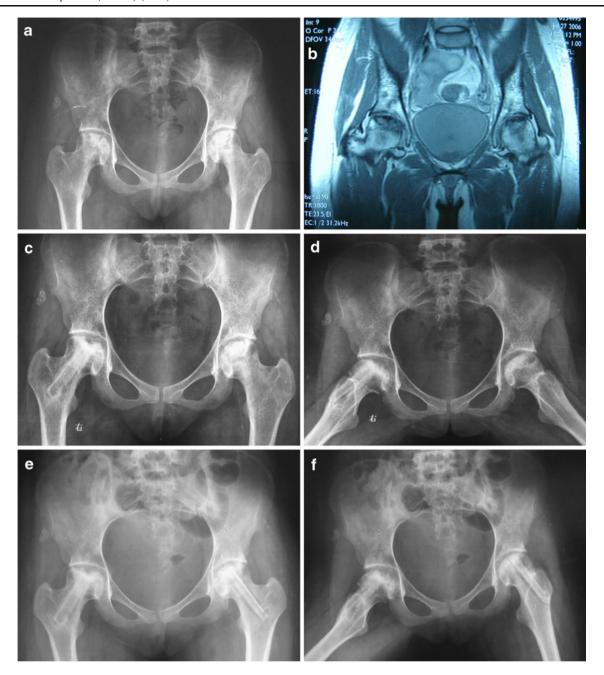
a A 19-year-old woman with non-Hodgkin's lymphoma and bilateral osteonecrosis (the right side was classified as stage IV, and the left side as stage III initially). Recurrent hip joint pain mainly focussed on the right side. The preoperative HHSs were 58 on the right side and 84 on the left. b Preoperative MRI of this patient. c, d Postoperative radiograph (anteroposterior and frog-leg position) 13 months after unilateral free vascularised fibular graft on the right
